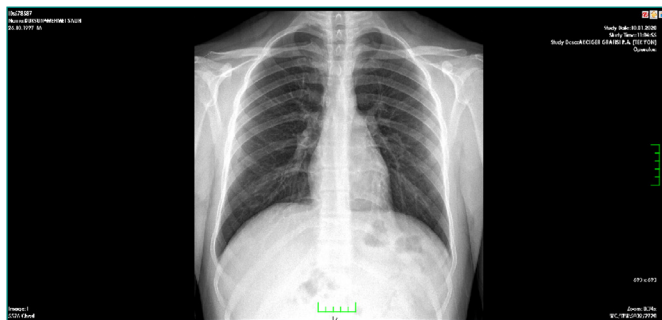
Preoperative PA chest X-ray.
